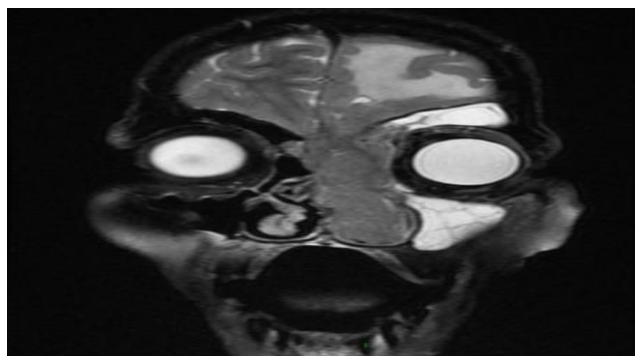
MRI PNS + brain (coronal view) showing extension of the SCC into the left frontal lobe.
